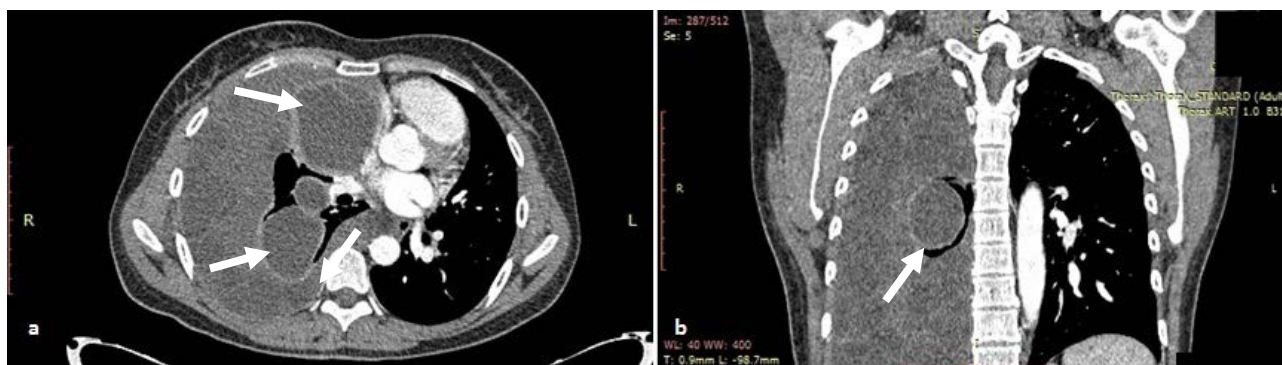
Chest computed tomography scan: a) axial view and b) coronal view, showing cystic formations in the right pleural space and in the upper and middle lobes of the right lung (arrows).
